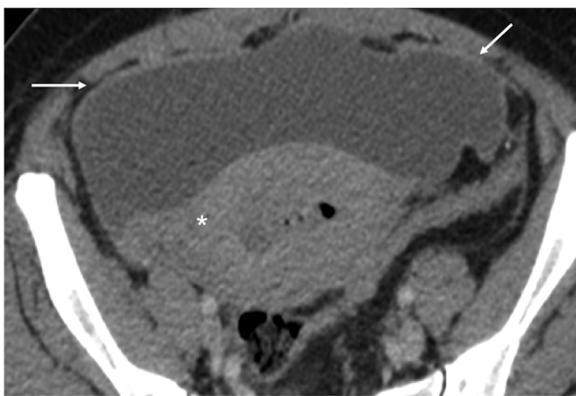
Peritonitis as a complication of endometritis. A 34-year-old woman on day 7 of the postpartum period who had persistent fever despite antibiotic treatment. CT with intravenous contrast shows loculated ascites and peritoneal enhancement (arrows). Enlarged uterus with contents and gas inside (*).
